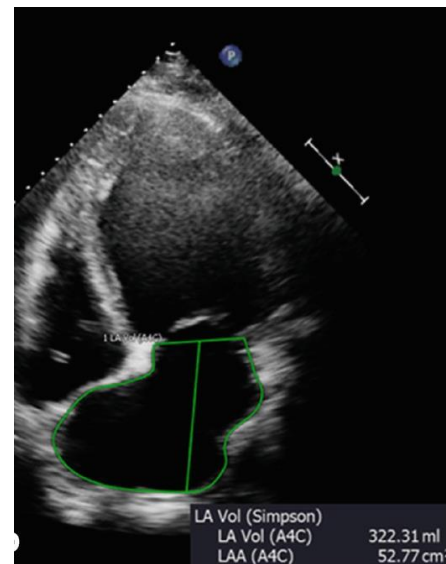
transthoracic echo in apical 4-chamber view, showing severe left atrial enlargement. Retrieved from Gil *et al.*, 2016.
